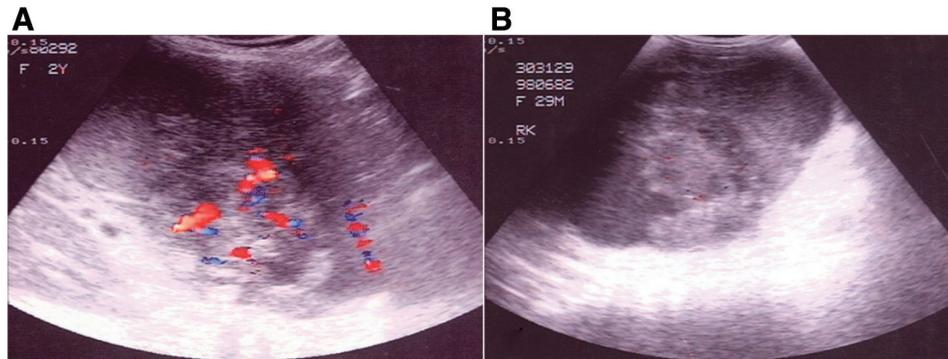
Color Doppler ultrasonography appearances of the left renal Wilms tumor in a 3-year-old boy. (A) Diffusely increased blood flow in the tumor before treatment. (B) Blood flow decreased significantly within the tumor after preoperative TACE and systemic chemotherapy.
